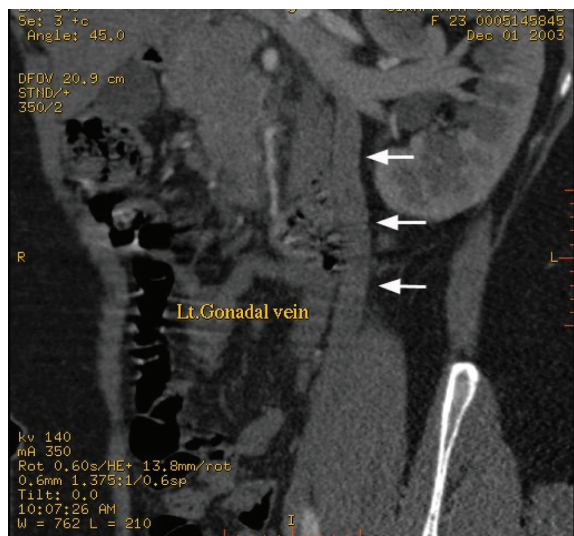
24-year-old female renal donor with oversized left gonadal vein. 3-D maximum-intensity-projection (MIP) CTA image demonstrates the oversized left gonadal vein (11 mm in diameter, white arrows) drained into left renal vein
